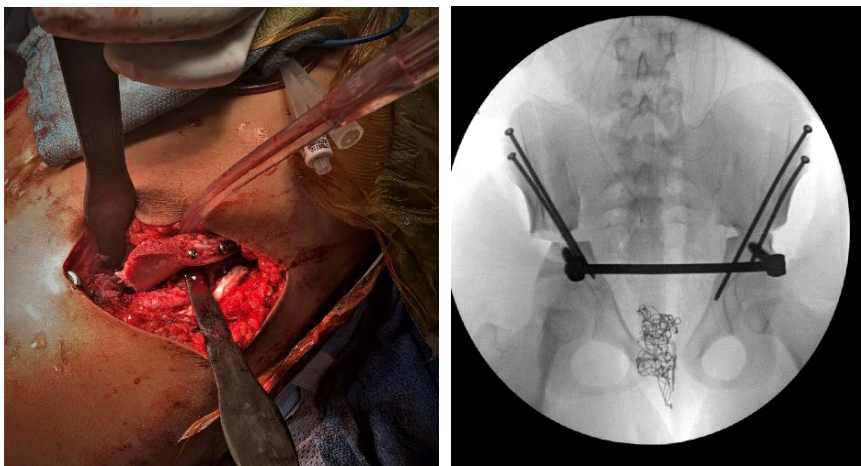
Clinical (A) and radiographical (B) images demonstrating supra-acetabular osteotomy fixation with cortical screws
